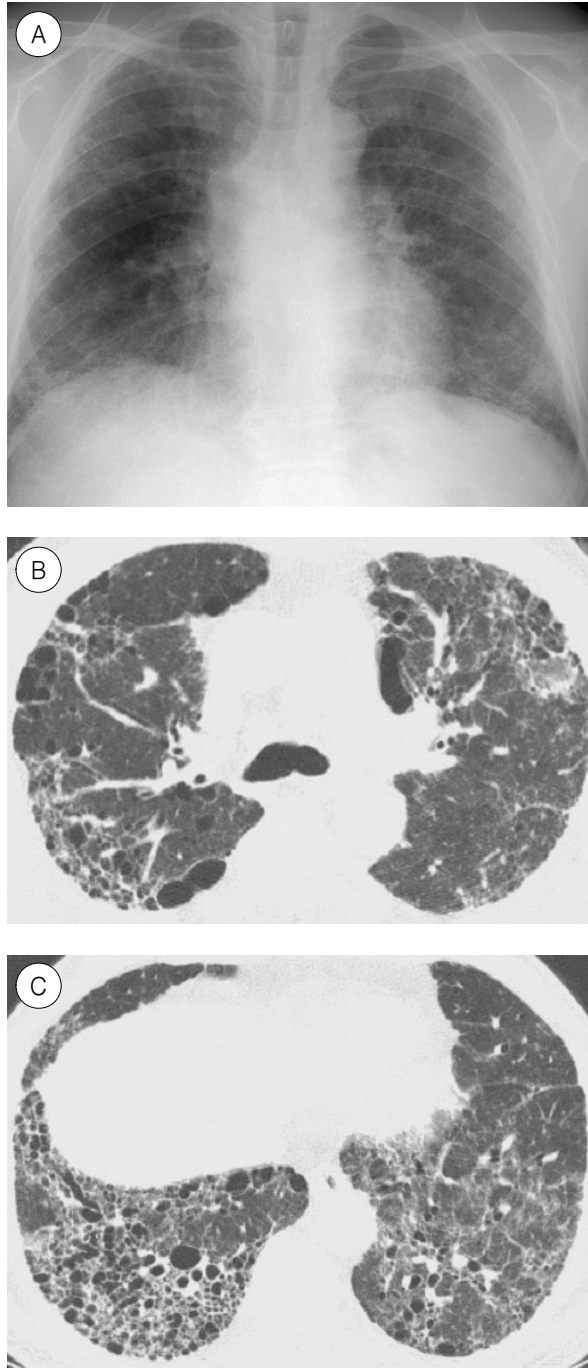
Idiopathic pulmonary fibrosis in a 54-year-old man. (A) Chest Radiograph shows peripheral reticular opacities in both middle and lower lung zones, with honeycombing. Mild volume loss of lower lobe is also noted. (B and C) HRCT scan shows basal and subpleural predominant reticular opacities with traction bronchiectasis, ground glass opacity and honeycombing.
